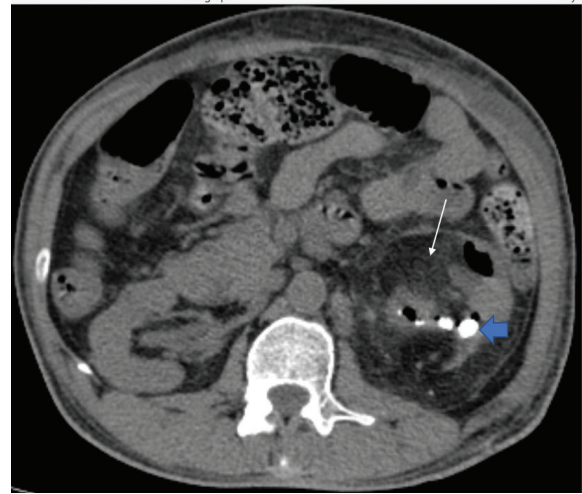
Axial non contrast CT through the level of bilateral kidneys shows fatty infiltration into the left renal pelvis and renal parenchyma (white arrow). Multiple calculi are noted in the left renal pelvis and adjacent calyces (blue block arrow).
